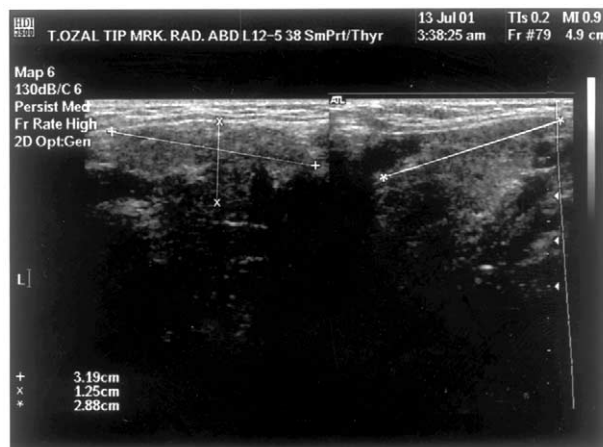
Ultrasonographic image of a submandibular gland in both planes: (+) paramandibular anterior–posterior length; (x) paramandibular depth; (*) frontal lateral–medial width.
